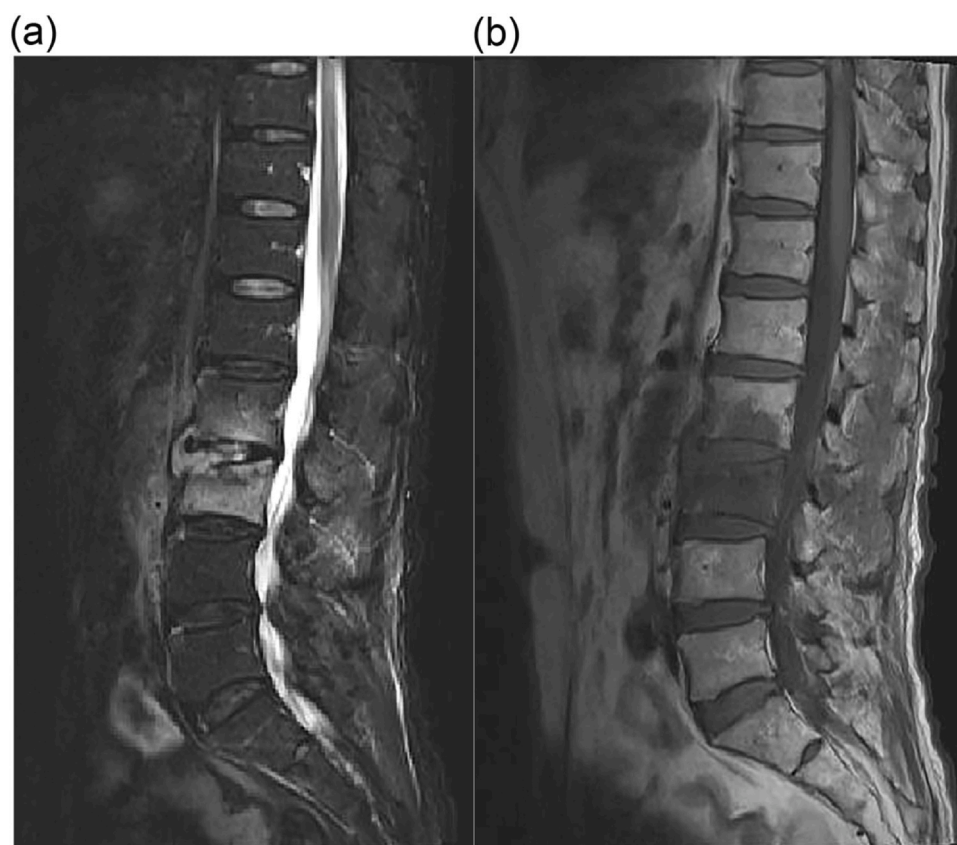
MRI showing increased signal intensity in STIR (A) and decreased signal intensity on T1-weighted imaging (B) in the L2 and L3 vertebral bodies and disc space.
